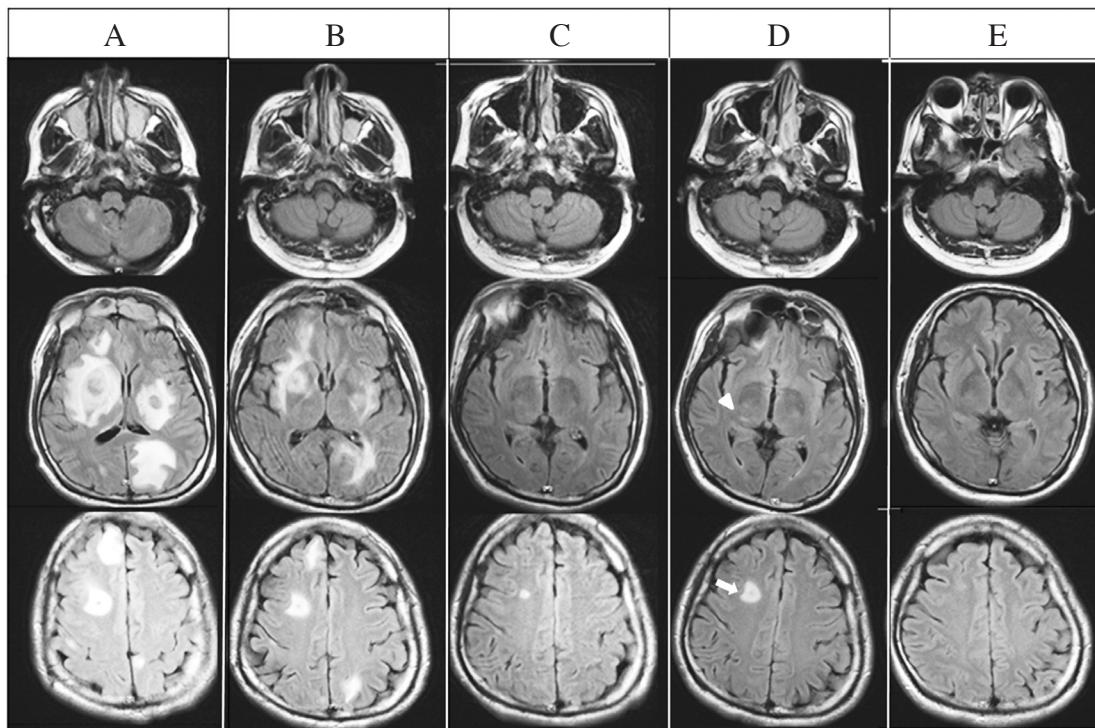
MRI of the brain in the study patient. A. MRI on admission revealing multiple enhancing lesions with marked perifocal edema in the right frontal lobe, bilateral parietal lobes, bilateral temporal lobes, bilateral occipital lobes, bilateral basal ganglia, right thalamus, and bilateral cerebellum. B-C. MRI showing improvement in mass lesions with empiric anti-*Toxoplasma* treatment. D. MRI taken when the patient had a worsening headache during treatment showing mild enlargement of the mass lesions with perifocal edema over the right hemisphere (arrows) and right basal ganglia (arrowhead). E. MRI taken after 5 months of anti-*Toxoplasma* therapy showing nearly complete resolution of the lesion and edema.
